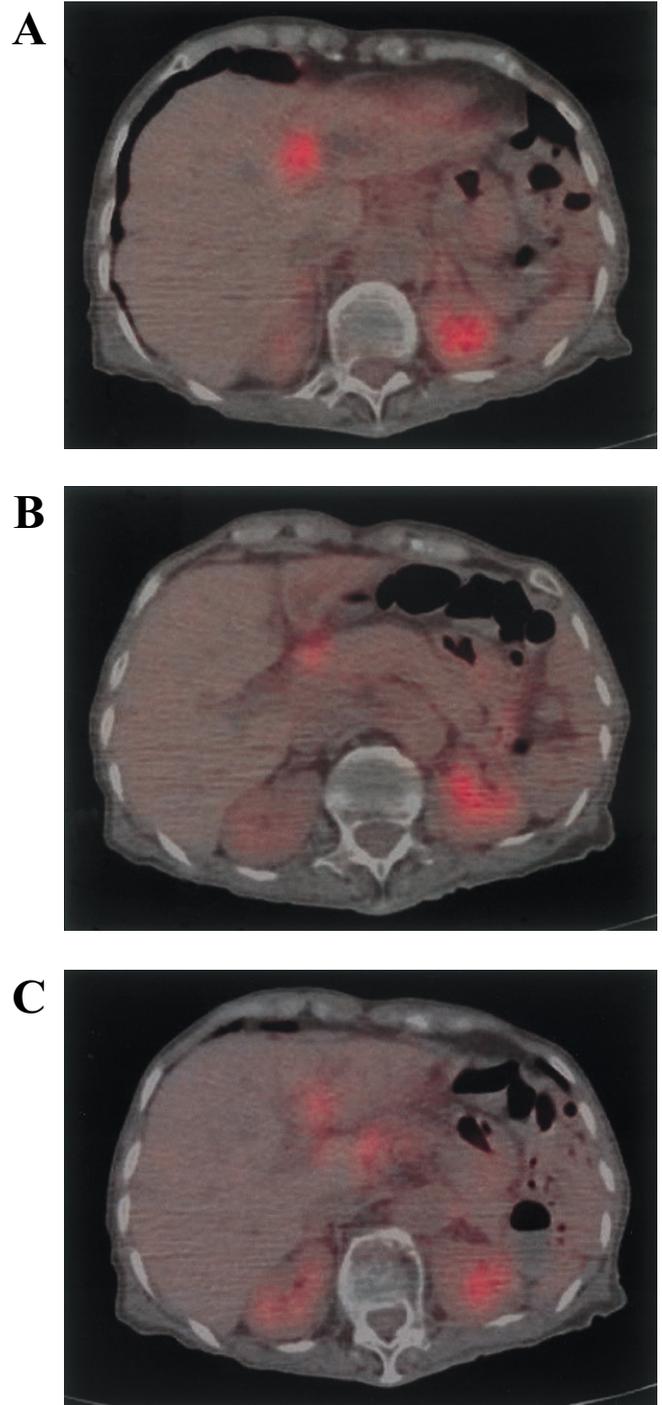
PET/CT imagings. A. PET/CT revealed increased glucose metabolic tumor in the hepatic hilar. B. PET/CT detected lymph nodes on the surface of the pancreas head. C. PET/CT showed lymph nodes in the hepatoduodenal ligament.
